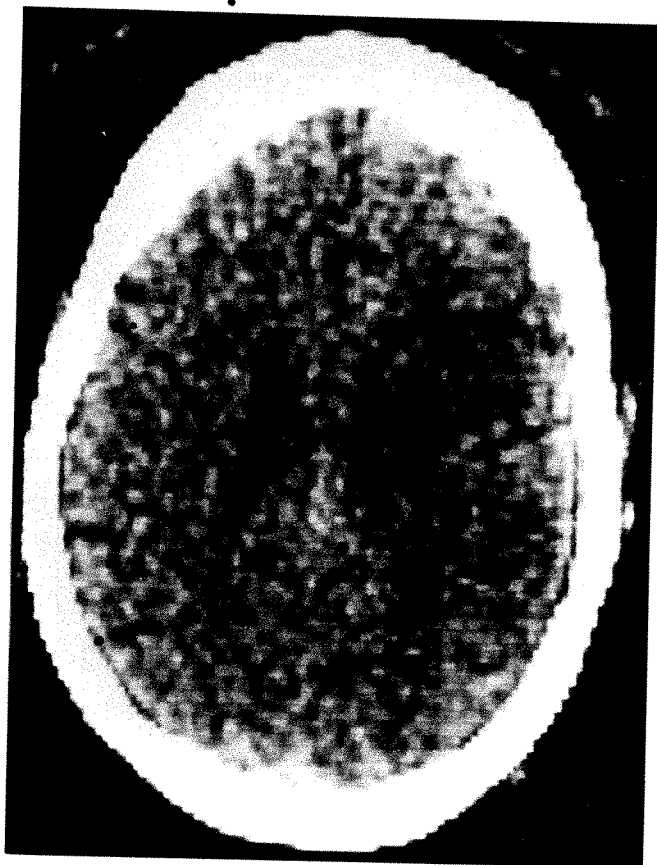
Infarction. 30-year-old male juvenile diabetic with sudden onset of left hemiparesis followed by progressive obtundation 30 days after onset of acute staphylococcal endocarditis with aortic insufficiency. Clinical diagnosis of brain abscess based on positive radionuclide brain scan. CT scan shows area of decreased density lateral to right lateral ventricle without mass effect. Subsequent hospital course prior to discharge showed slow improvement in neurological status and negative cultures of cerebrospinal fluid. Follow-up CT and radionuclide brain scans demonstrated infarction.
